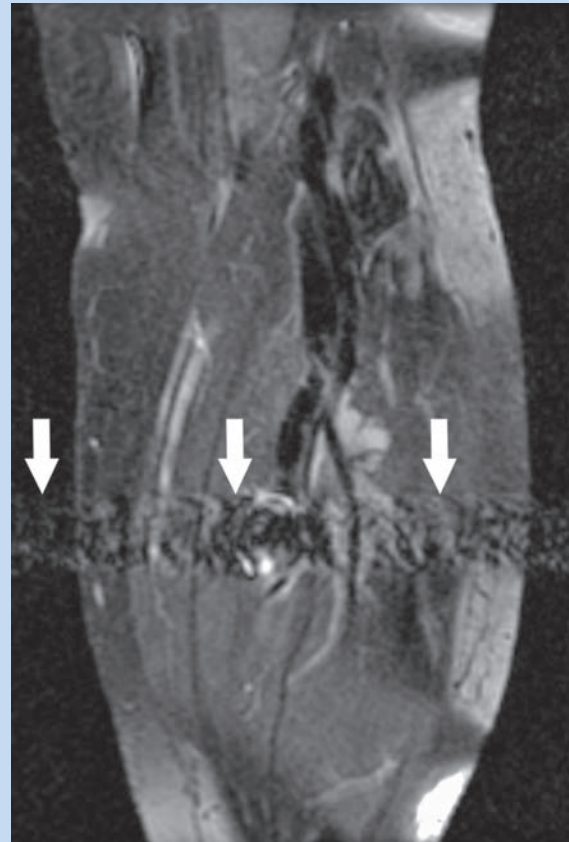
MRI of the calf demonstrating a region of high flow as signal voids with phase encoding artifact (arrows).
